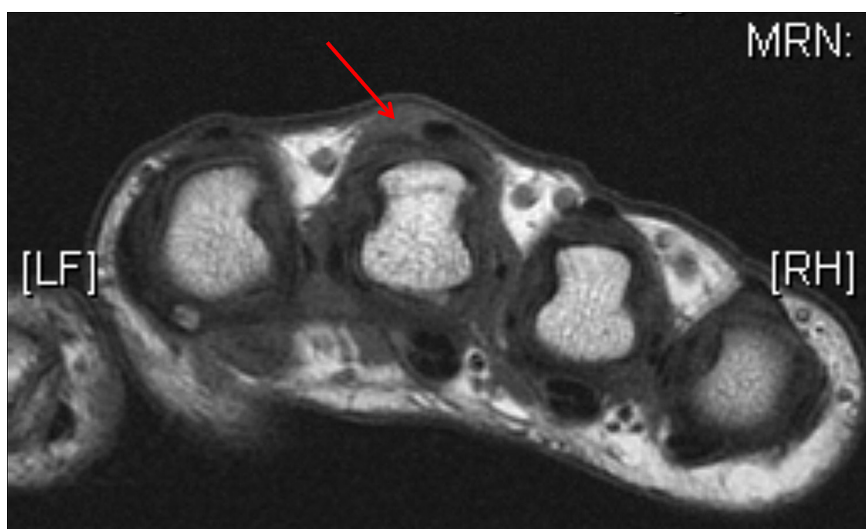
MRI confirming injured radial sagittal band (red arrow) and subluxation of central tendon (Case 1).
